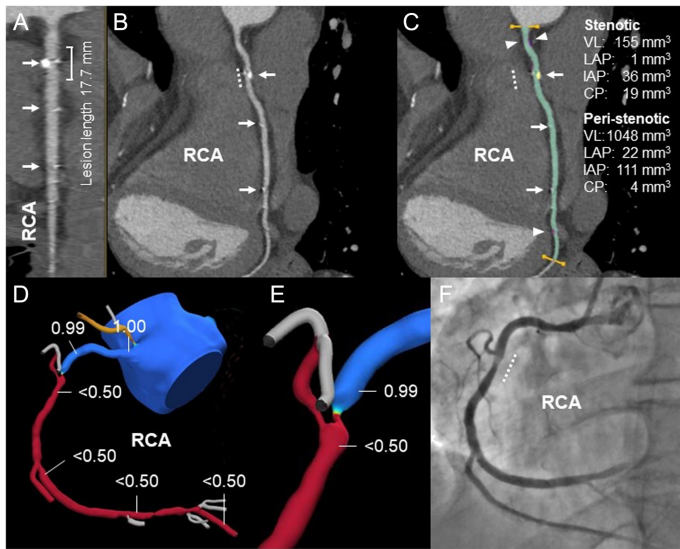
Case 2. The dotted line, arrowhead, and arrow indicate stenotic lesion, IAP, and CP, respectively. CP, calcified plaque; CTA, computed tomography angiography; FFR_{CT}, fractional flow reserve-derived computed tomography; IAP, intermediate-attenuation plaque; LAP, low-attenuation plaque; RCA, right coronary artery; VL, vessel lumen.
